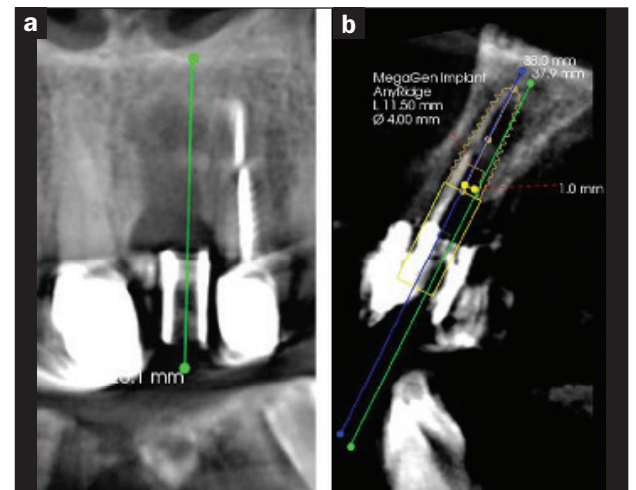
CBCT scan of the guide sleeve following correction of the implant trajectory in the planning software to a better position in relation to the available bone of the site (green line) that is offset 1.0 mm facially and 0.5 mm mesially from the initial trajectory (blue line), a 1.06-mm correction mesiobuccally.
